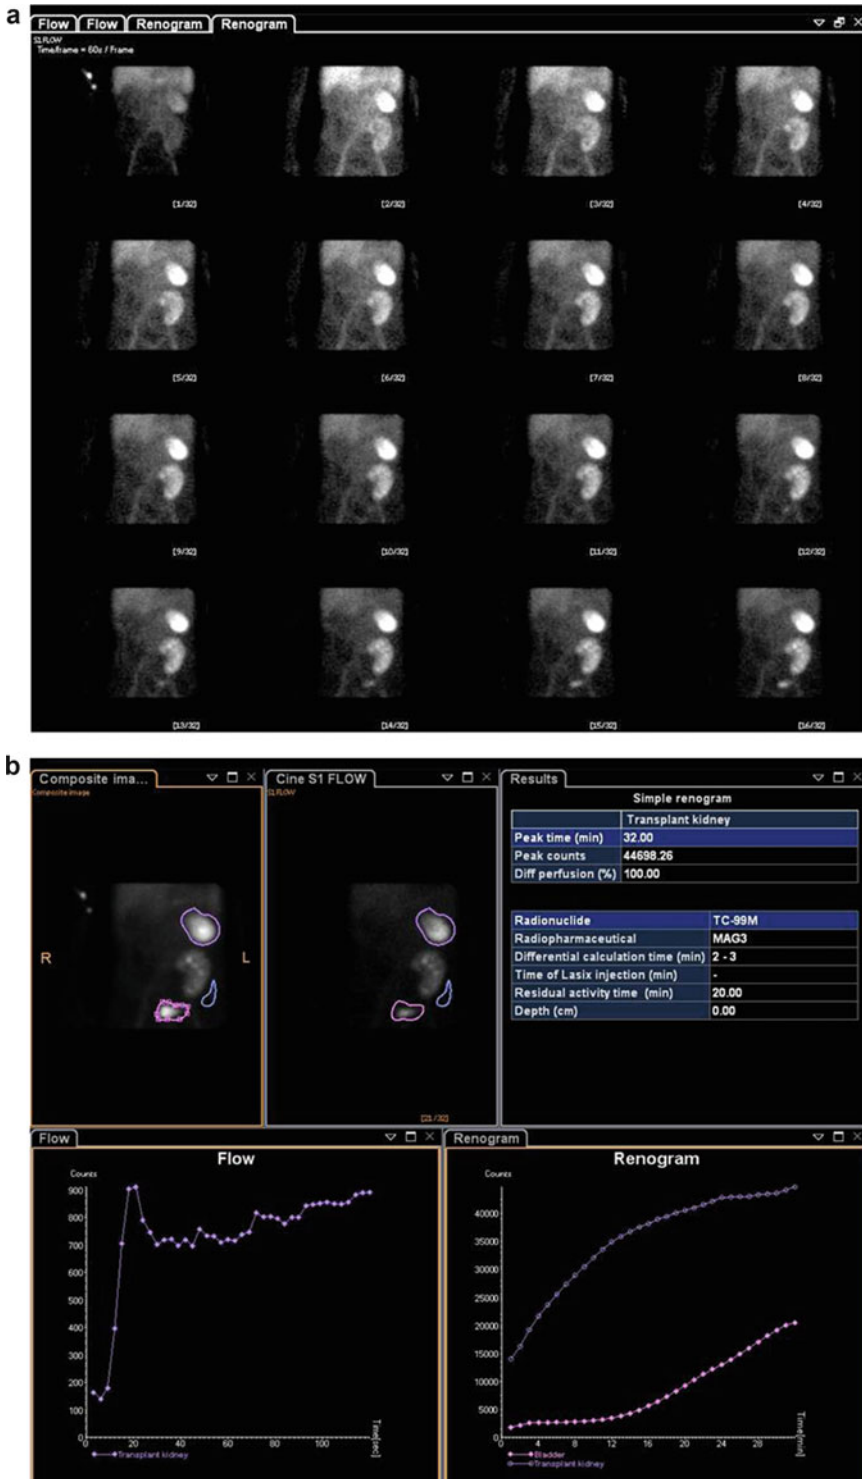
Renal scintigraphy in acute tubular necrosis. (a) Serial images obtained during the renographic phase show progressive cortical radiotracer uptake without excretion.
